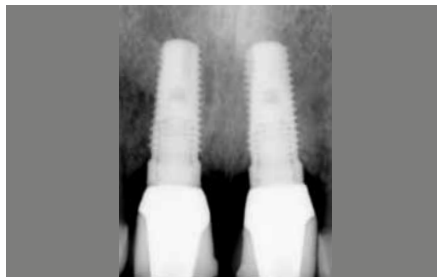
Final radiograph 2005.
